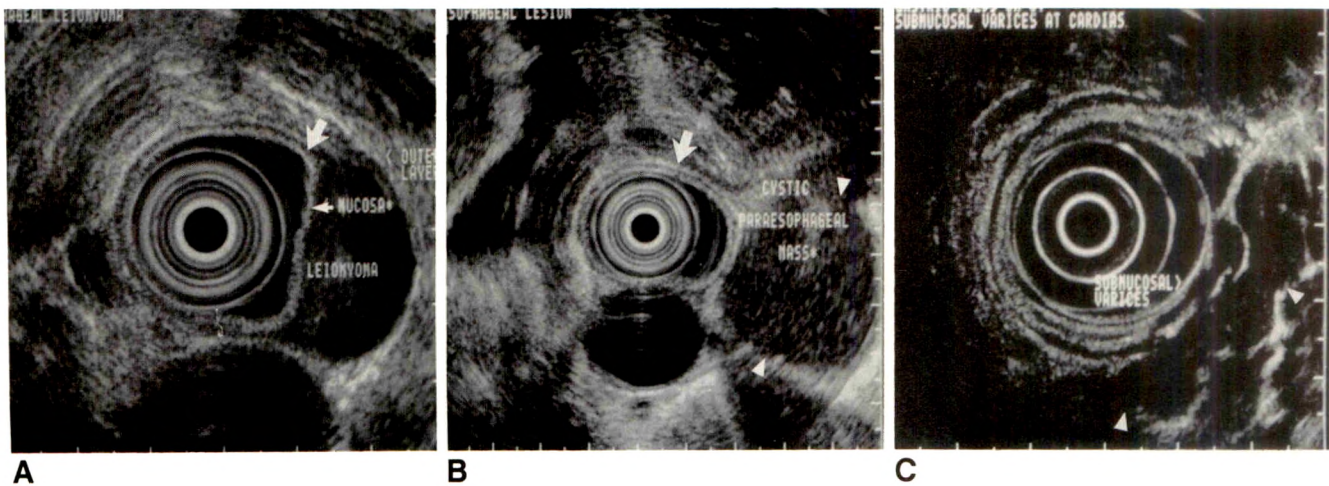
Endoscopic sonography of benign conditions of esophagus with 7.5-MHz transducer.
